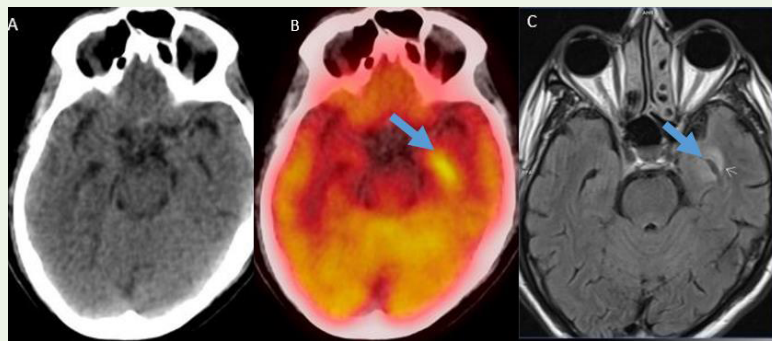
Image A and B: FDG PET scan shows increased FDG uptake in the left mesial temporal lobe. Image C: MRI Brain showing T2 hyperintensity in the corresponding area. Image B and C: DWI demonstrating a lesion in the genu of corpus callosum with restricted diffusion.
